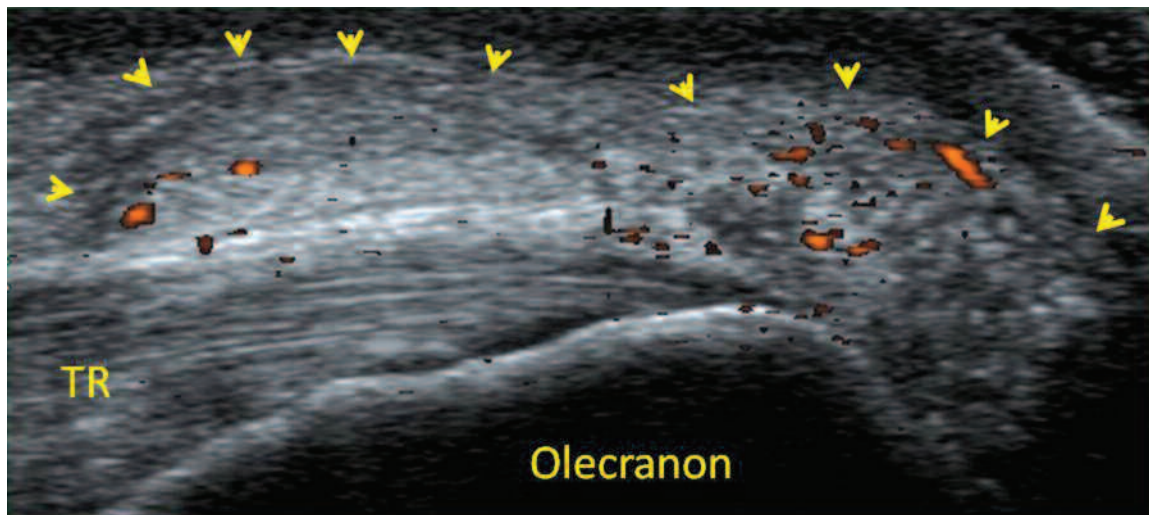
Affected right elbow: hyperechoic material representing monosodium urate tophus (arrowheads) is seen overlying insertion of triceps tendon (TR) into olecranon. Power Doppler signals indicated hyperemia.
